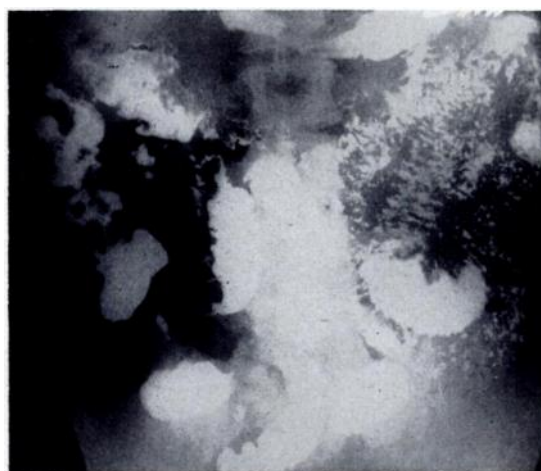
Roentgenogram of the small bowel in a typical case of non-tropical sprue. The "sprue pattern" is characterized by considerable dilatation of the loops segmentation and evidences of hypersecretion. (From: ADLERSBERG, D., MARSHAK, R. H., COLCHER, H., DRACHMAN, S., FRIEDMAN, A. I. and WANG, C.-I. *Gastroenterology*, 26: 548, 1954.⁴)
